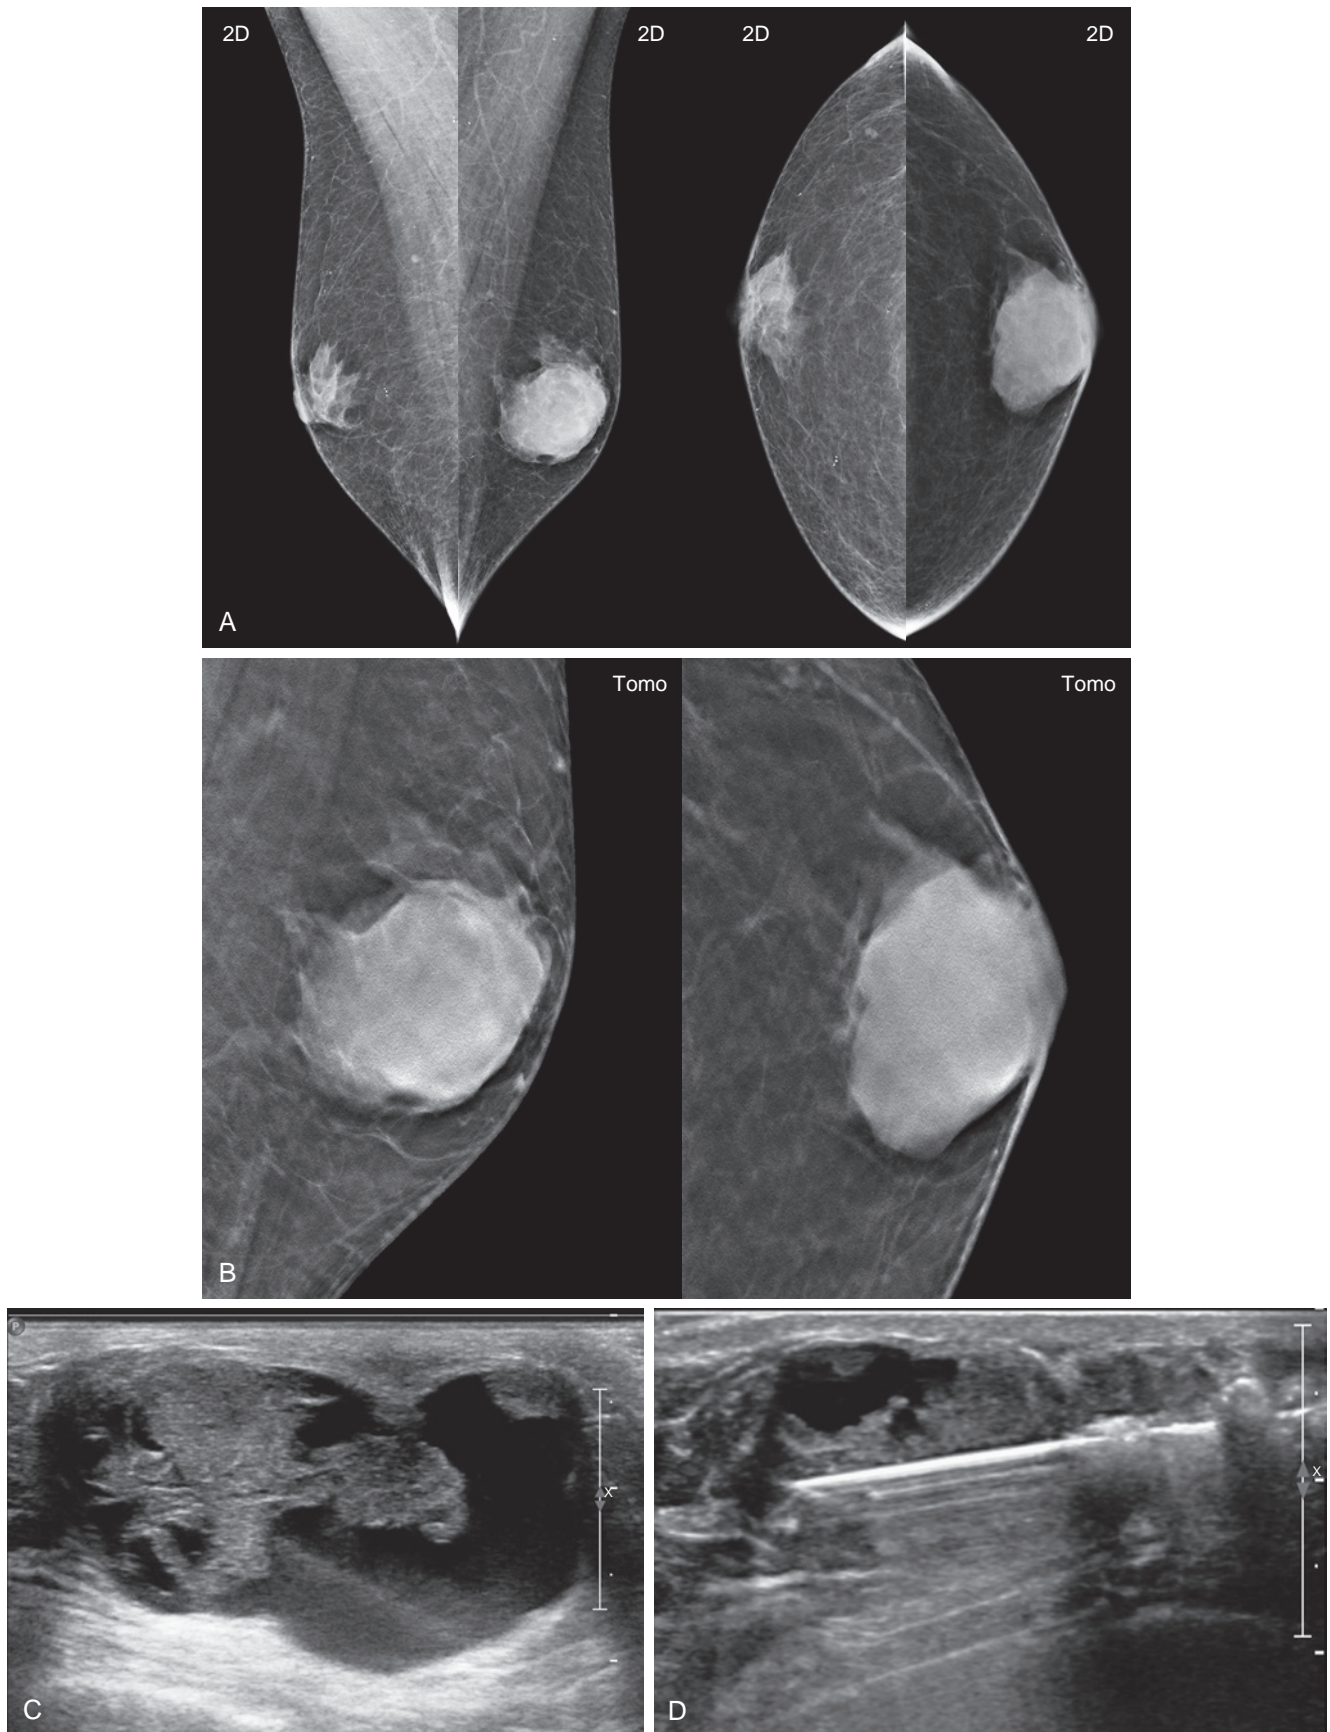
Ductal carcinoma in situ. A 71-year-old man presents with a palpable left breast mass. (A) 2D mammography shows nodular gynecomastia bilaterally and a 3-cm lobulated mass corresponding to the palpable lump. (B) Tomosynthesis slice images show that the margins are predominantly circumscribed. (C) Ultrasound reveals a complex cystic and solid mass. (D) Ultrasound-guided core needle biopsy was performed showing ductal carcinoma in situ. Final pathology revealed papillary carcinoma with foci of invasive carcinoma, mucinous type, ER/PR/AR+, Her2-.
